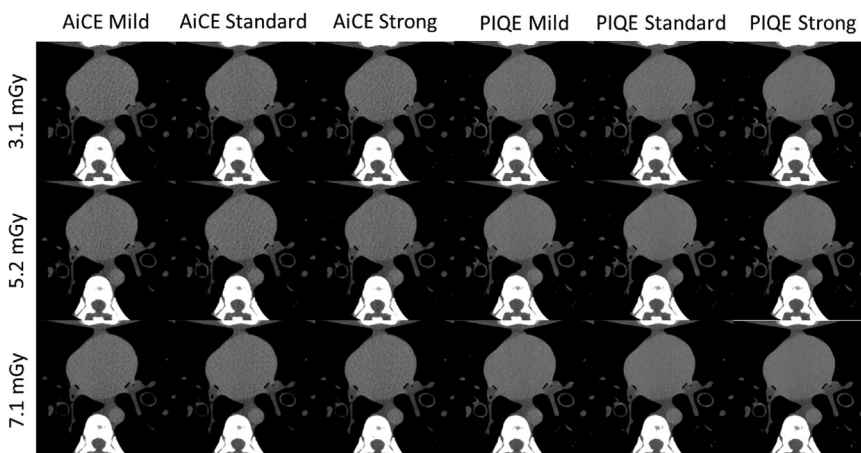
Figure show axial anthropomorphic CT images (WL: 400 HU, WW: 40 HU) obtained for all levels of AiCE and PIQE and the three dose levels.
